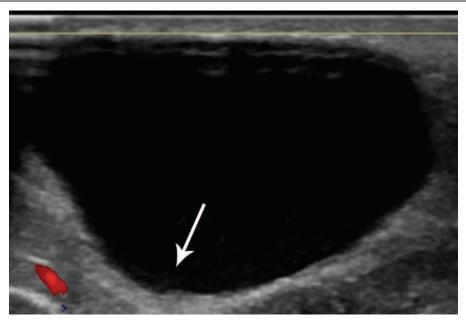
B-mode ultrasound revealed a simple cyst with locally unsmoothed cyst wall (arrow).
